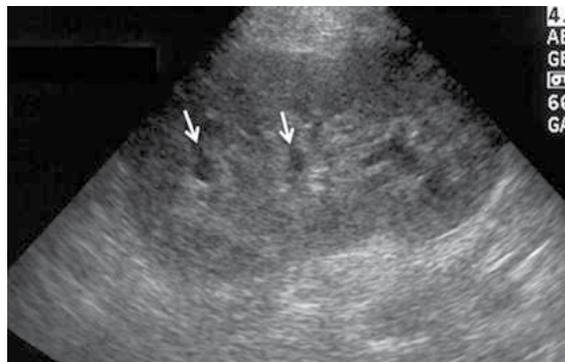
Normal sonographic appearance of a renal allograft in the immediate post-transplant period. Notice the mild dilatation of calyceal system (arrows).
